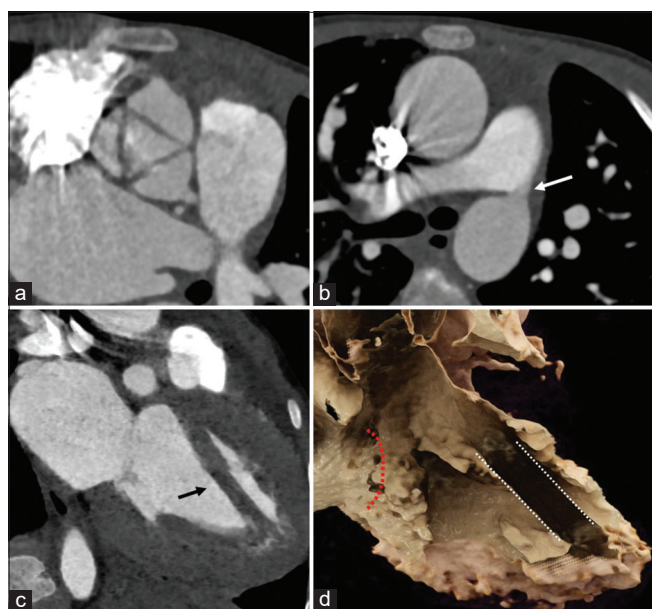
Contrast-enhanced cardiac computed tomography images: (a) Showing thickened aortic valve leaflets, (b) showing patent ductus arteriosus (marked in white arrow), (c) showing the left ventricular false tendon, and (d) showing the left ventricular false tendon (marked by white dashed lines) in relation to the mitral valve (marked by red dashed line).
